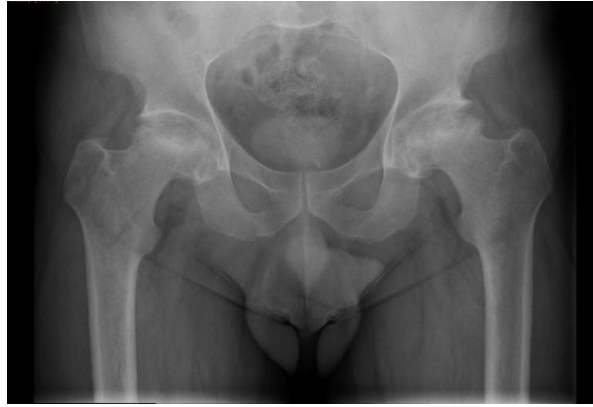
Anteroposterior radiographs of the hip joints: grade II/III bilateral osteoarthritis, secondary to avascular necrosis of the femoral head: joint space narrowing, subchondral sclerosis of acetabulum , osteophytes, flattening of the femoral head, with inhomogeneous bone structure - sclerosis and changes in bone density.
